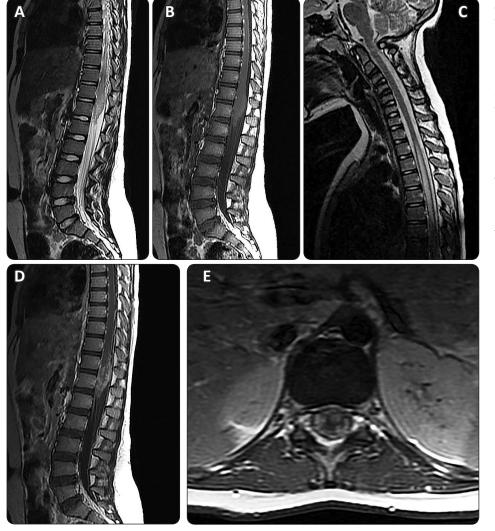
A,B: MRI T2, T1 weighted images showing diffuse hyper intense swelling of the conus medullaris and adjacent spinal ord. C: Sagittal T2weighted MRI showing associated hyperintense signal involving the spinal cord extend to the whole dorsal cord area indicating associated oedema due to inflammatory reaction. D,E: T1 sagittal and axial postcontrast MRI showing Nodular intramedullary and peripheral enhancement of the distal cord and conus medullaris .Peripheral enhancing lesions correlated to thickened leptomeninges infested by chronic granulomatous inflammatory cells and schistosoma eggs.
